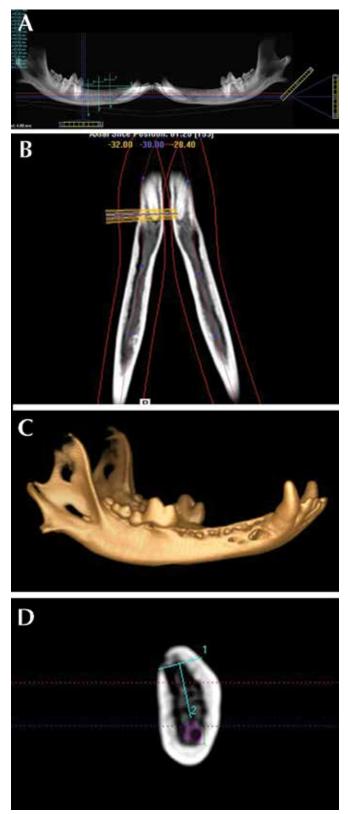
CBCT images of the beagle mandible. (A) Lingual view. (B) Maxillofacial view. (C) Buccal view. (D) Cross-sectional view.
